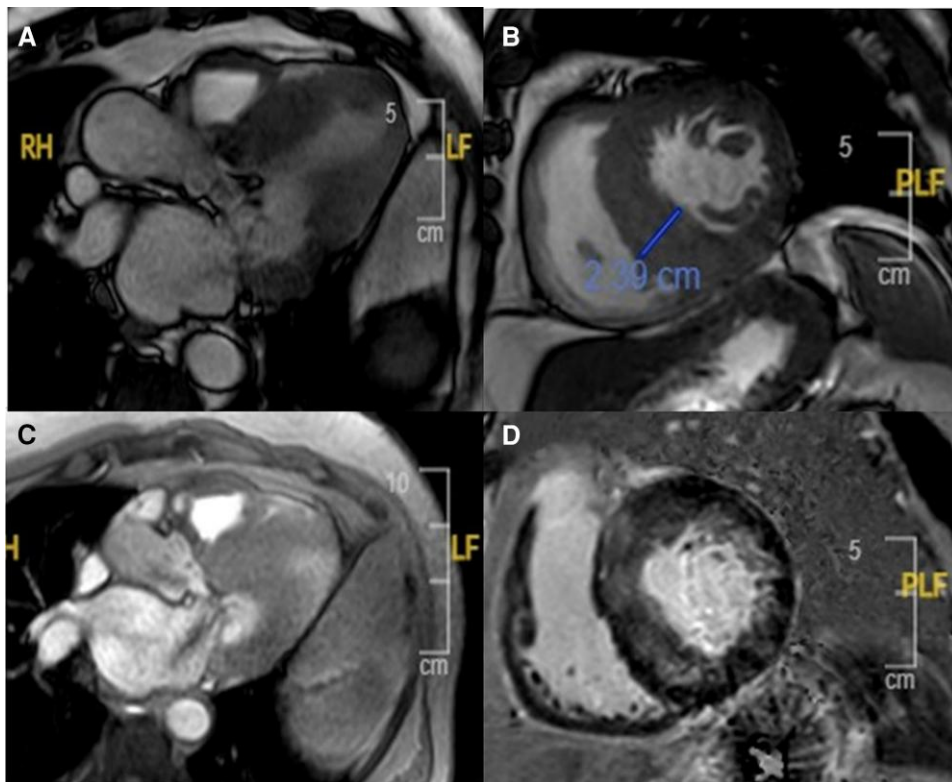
(A–D) Cardiac magnetic resonance imaging with cine imaging confirming septal hypertrophy with systolic anterior motion–related mitral regurgitation. Post-contrast imaging showing extensive non-ischaemic scar in hypertrophied segments.
